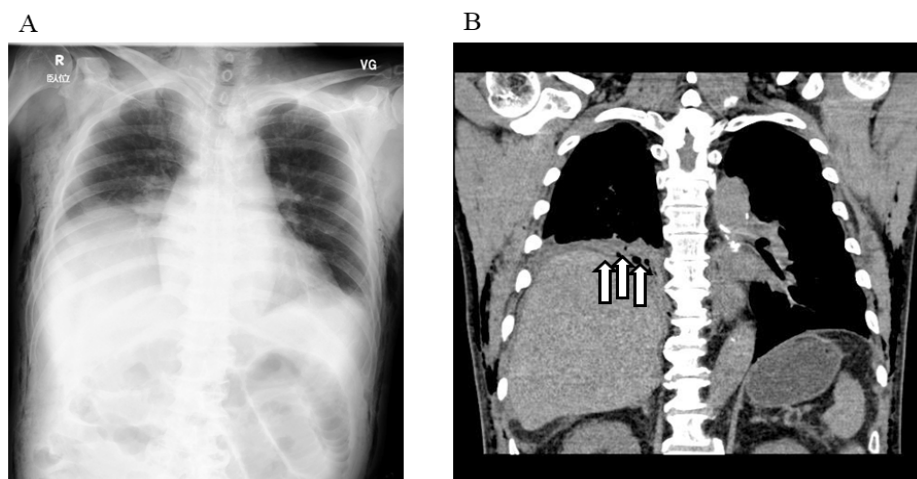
Chest radiograph (A) and CT (B) on the first postoperative day. Significant elevation of the right diaphragm was still observed and CT clearly showed atelectasis of the inferior lobe of the right lung (arrow).
